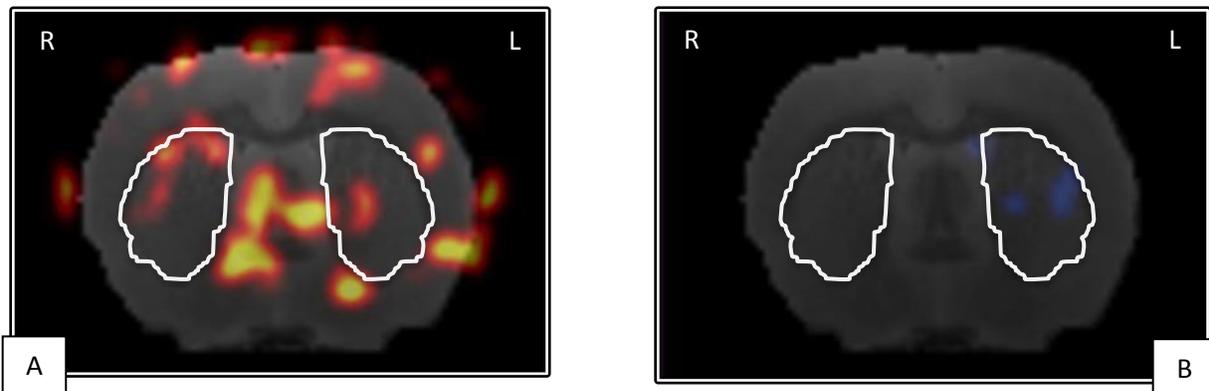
PET-FDG image of the striatum.
